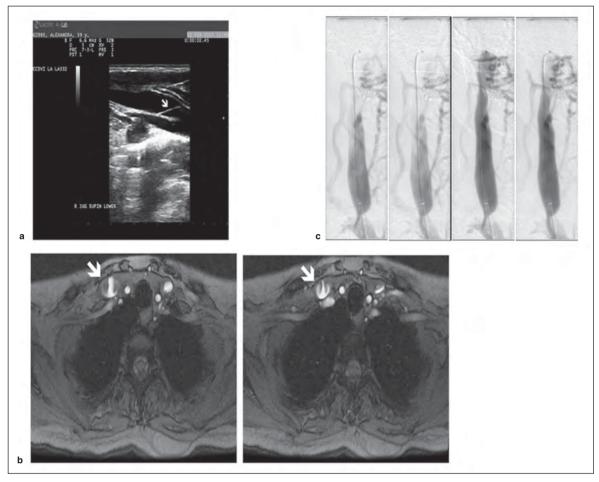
Internal jugular vein narrowing within the valvular zone of the lower segment. (a) Longitudinal ultrasound image of the lower left internal jugular vein with septum (arrow) coursing across the transverse extent of the vessel adjacent to the valve. This abnormality is one of many that is increasingly recognized in the constellation of intraluminal lesions associated with the valvular region of the lower jugular. Many of these are associated with venous obstruction, flow abnormalities and a diagnosis of CCSVI. (b) Axial images from an MR venogram of the neck show prominent valve cusps (arrows) within the right internal jugular vein at the base of the neck. Conspicuous valvular architecture evident on MR imaging may be associated with a narrowed valvular orifice that is observed with other imaging modalities. (c) Right internal jugular venogram with fixed narrowing of the valve and obstruction to jugular venous drainage. Delayed emptying of the jugular vein following contrast injection and the presence of a robust collateral network are associated with the jugular venous insufficiency.
